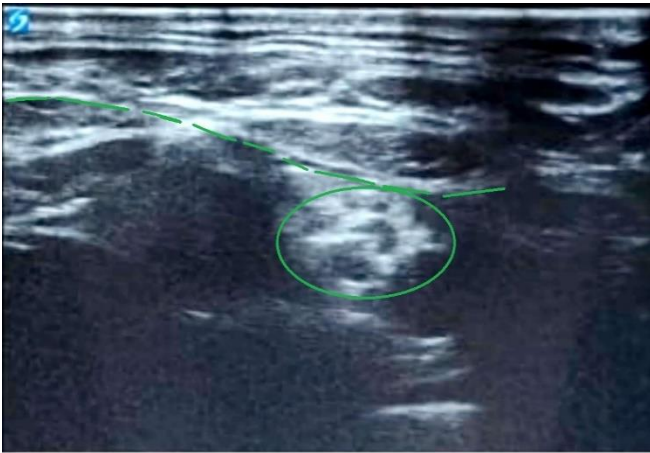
Ultrasound image marking the catheter site and brachial plexus.
